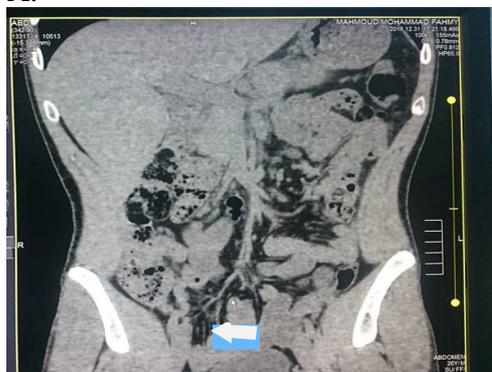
A. Graded compression longitudinal ultarsound scan of acute appendicitis with dilated, non compressible, bilnd end, tubular appendix with thickening of the appendicular wall. B.and C. Axial and coronal CT cuts demonstrated dilated appendix with distended lumen more than 6 mm, thickeened, enhancing wall and periappendicular inflammation including strandling of the adjacent fat.
